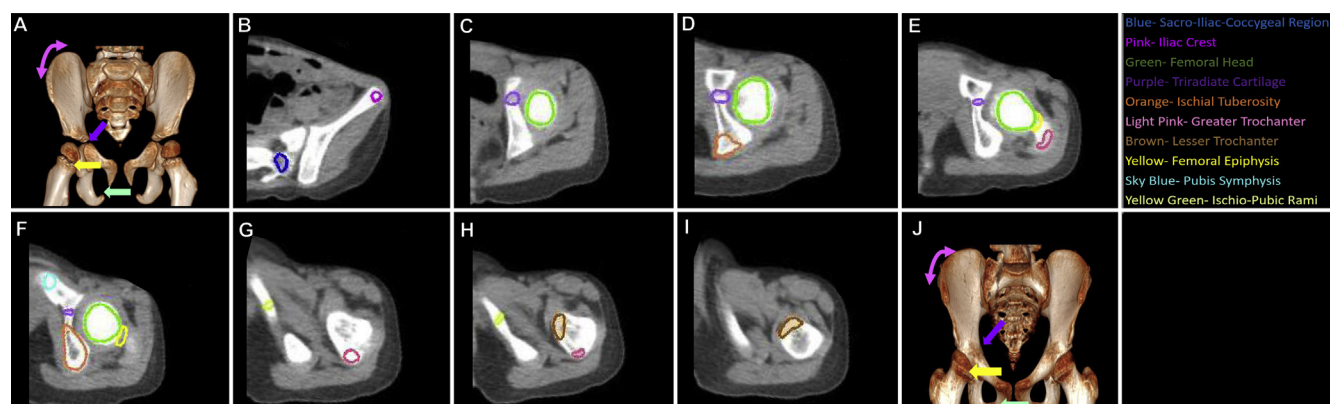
Important ossification centers of the pelvis in an anterior (A), 3-dimensional, reconstructed computed tomography scan of a 2-year-old male patient, with axial computed tomography slices showing contours of the centers of growth (B-I) progressing in the craniocaudal direction. Growth is near complete, with ossification centers fused, in the depicted scan from the 12-year-old female patient (J).
